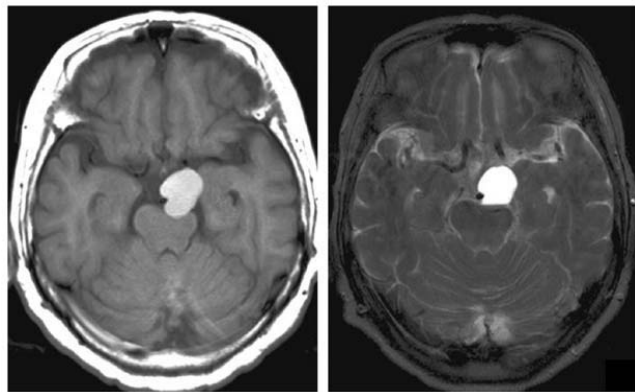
Seven months after initial onset, axial unenhanced MRI shows enlargement of the cyst. T_1 -weighted imaging (left) and T_2 -weighted imaging (right) also show homogeneous signal intensity and tumor size reaching 22 mm in diameter during this period.
